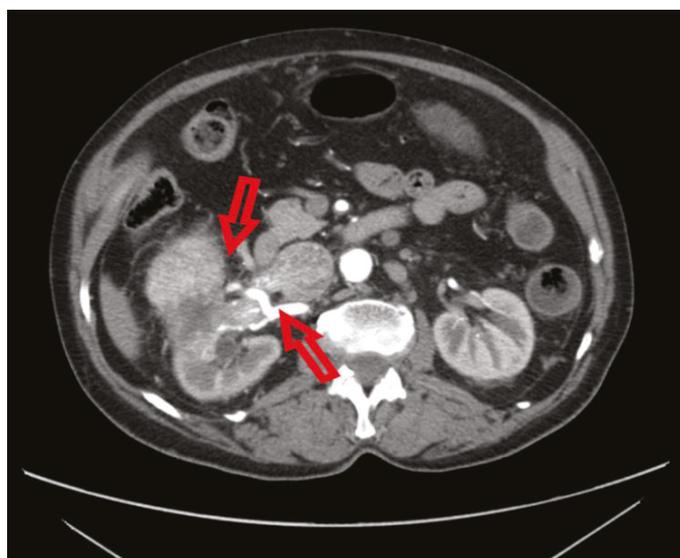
Abdominal CT with contrast, cross-section – right kidney tumor, tumorous masses in the right renal vein and inferior vena cava (arrows).
